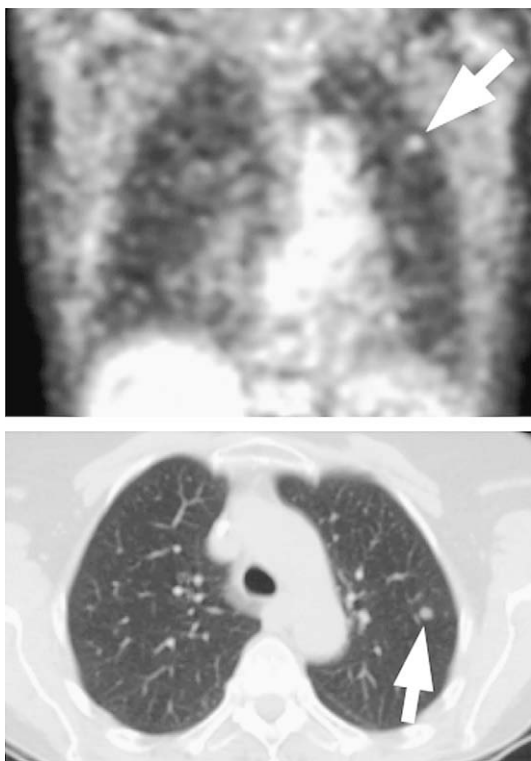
A 69-year-old woman operated on 16 months before for a T3N2 sigmoid adenocarcinoma, presenting with an increasing CEA level (12 ng/mL). Whole-body FDG PET-CT shows a hot spot in the upper part of the left lung (*top, arrow, coronal view*), corresponding to a 6-mm nodule on the low-dose CT (*bottom, arrow*). This turned out to be a lung metastasis.
